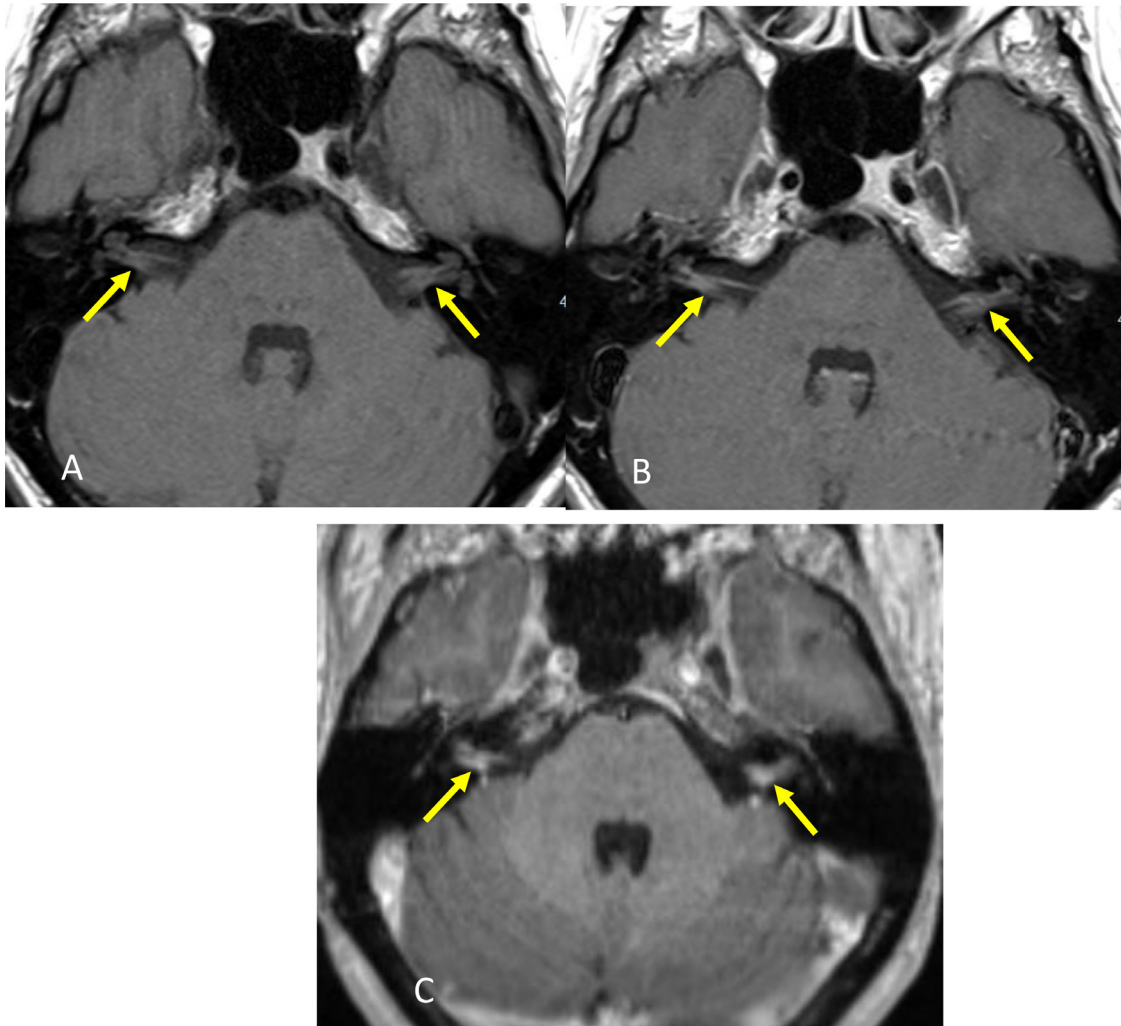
Pre-contrast (A), post-contrast (B) axial T1-weighted images and axial post-contrast (C) T1-weighted MPRAGE image show enhancement of the 7th and 8th cranial nerves within the internal auditory canals bilaterally. (arrows).
